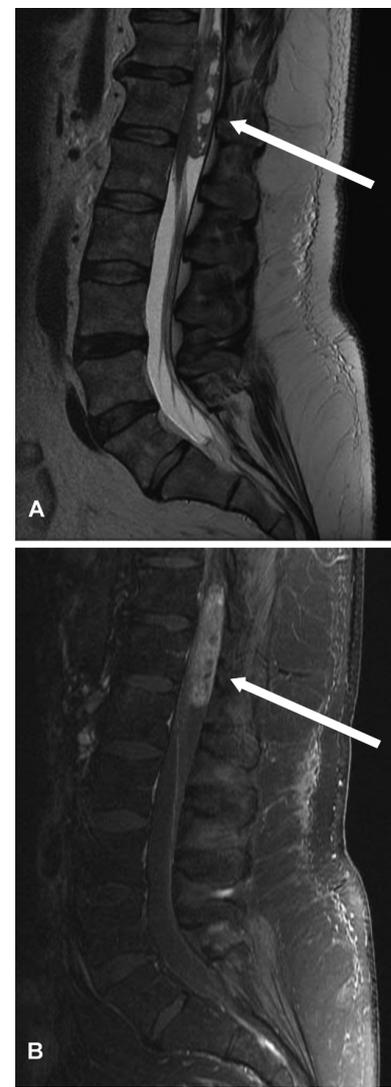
Case #2 – Lumbar MRI, Fast-spine echo T2 (A) and T1 with gadolinium contrast (B), demonstrating a heterogeneous, enhancing, sausage shaped intradural extramedullary tumor.
